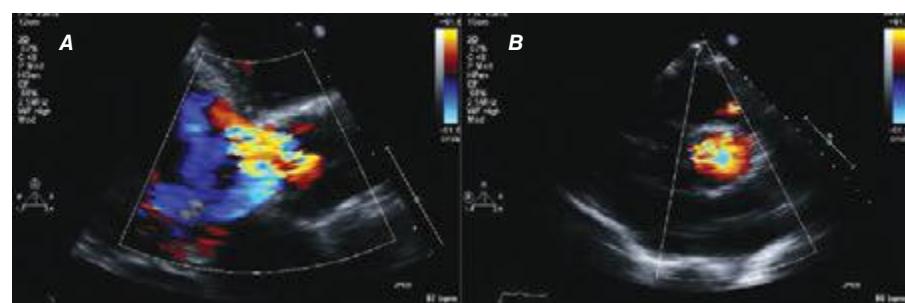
20 Aortic regurgitation visualized by color flow Doppler in the parasternal long-axis view (A) and the parasternal short-axis view (B).
